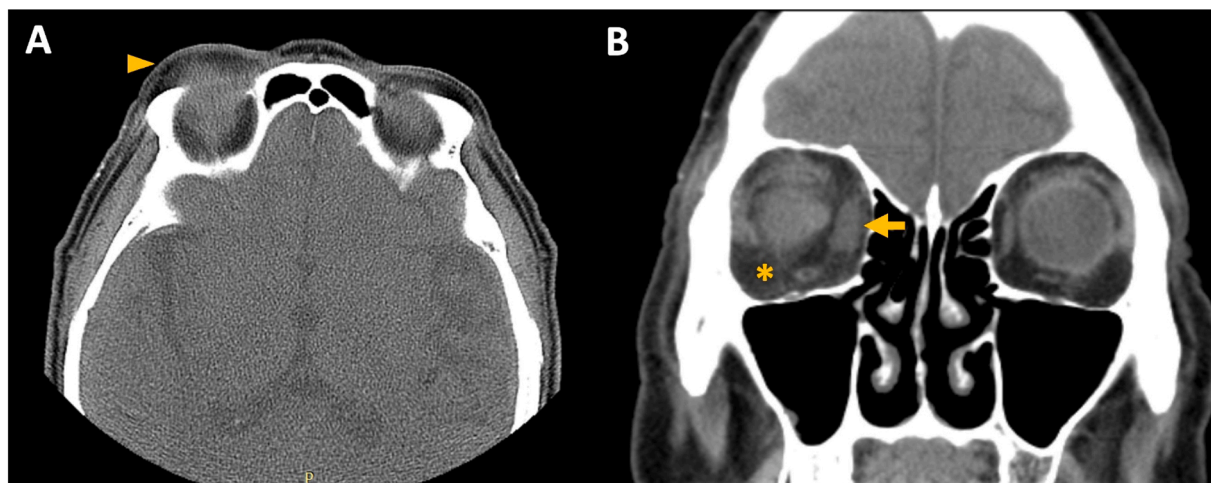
Shows an orbital computed tomography (CT) in the axial (A) and coronal (B) planes showing palpebral/periorbital edema (arrowhead), intraconal stranding (orbital cellulitis) (asterisk) and medial rectus enlargement (orbital myositis) (arrow) in the right eye of a 77-year-old male patient with VEXAS syndrome.
